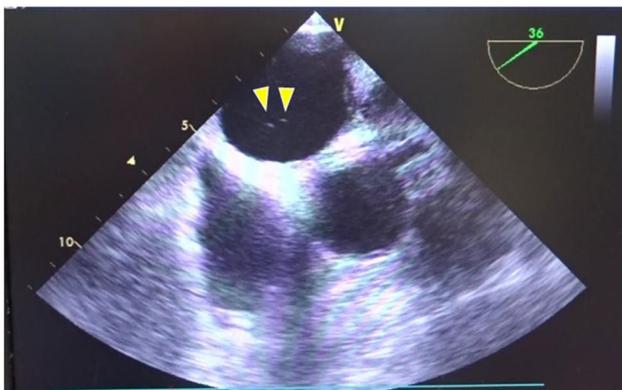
Air bubbles were detected in the left atrium on transesophageal echocardiography. The patient was a 64-year-old man with multiple metastases to the lung with renal cell carcinoma, who underwent the resection of seven nodules from the right lung. We performed wedge resection via video-assisted thoracoscopic surgery. When the lung parenchyma was cut using a stapler, we identified air bubbles during transesophageal echocardiography
